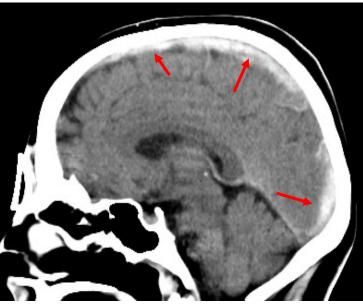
Extensive superior sagittal sinus thrombosis as seen on non-contrast CT. The acute thrombus appears hyperdense and is indicated by arrows.
